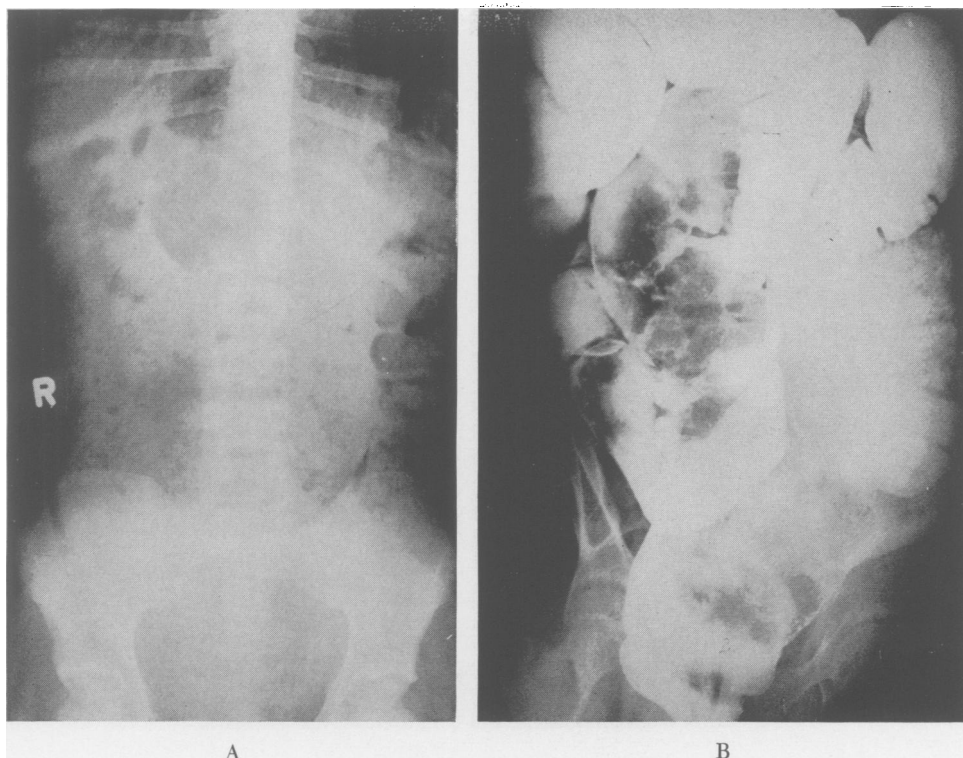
Girl of nine admitted to the hospital with obstinate constipation since early childhood and two episodes of urinary retention. A. (Left) Plain film showing huge feces filled loop. B. (Right) Barium enema showing voluminous redundant, greatly dilated colon and rectum down to anus. Child was placed on regimen of daily enemas and within a short period of time was having a spontaneous daily evacuation.
